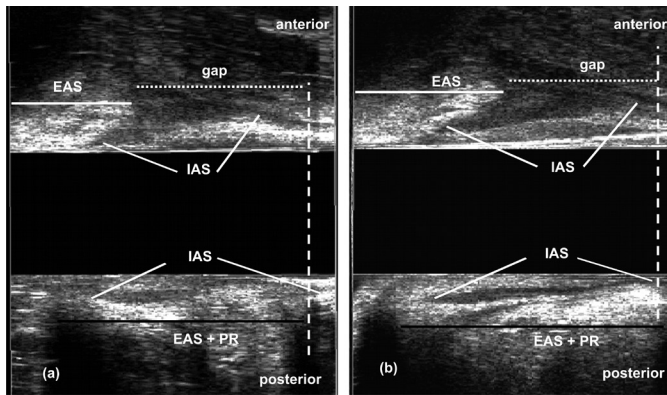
Measurements of sphincter lengths by 3-Dimensional anal ultrasonography (sagittal plane). (A) Patients with previous vaginal delivery and intact sphincters (sagittal plane). (B) Nulliparous voluntary (sagittal plane). EAS: external anal sphincter; IAS: internal anal sphincter; EAS+PR: external anal sphincter plus puborectalis muscle
